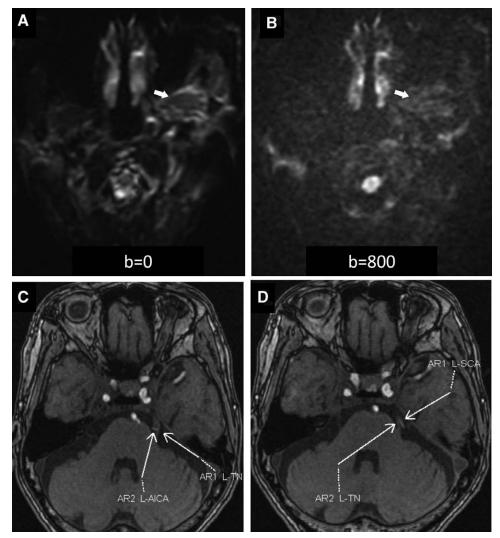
Lateral pterygoid muscle edema in a patient with left-sided TN. (A and B) DWI images obtained in a patient with left-sided TN, showing the signal intensity of left lateral pterygoid muscle was obviously high (white arrow). With the increase of B value, DWI image grain becomes thicker, muscle signal decreases, and image quality decreases. (C and D) MRTA scans showing the left anterior inferior cerebellar artery and superior cerebellar artery was closely related to the left TN, and the space between blood vessels and nerves was smaller than the diameter of blood vessels. DWI = diffusion weighted imaging.
